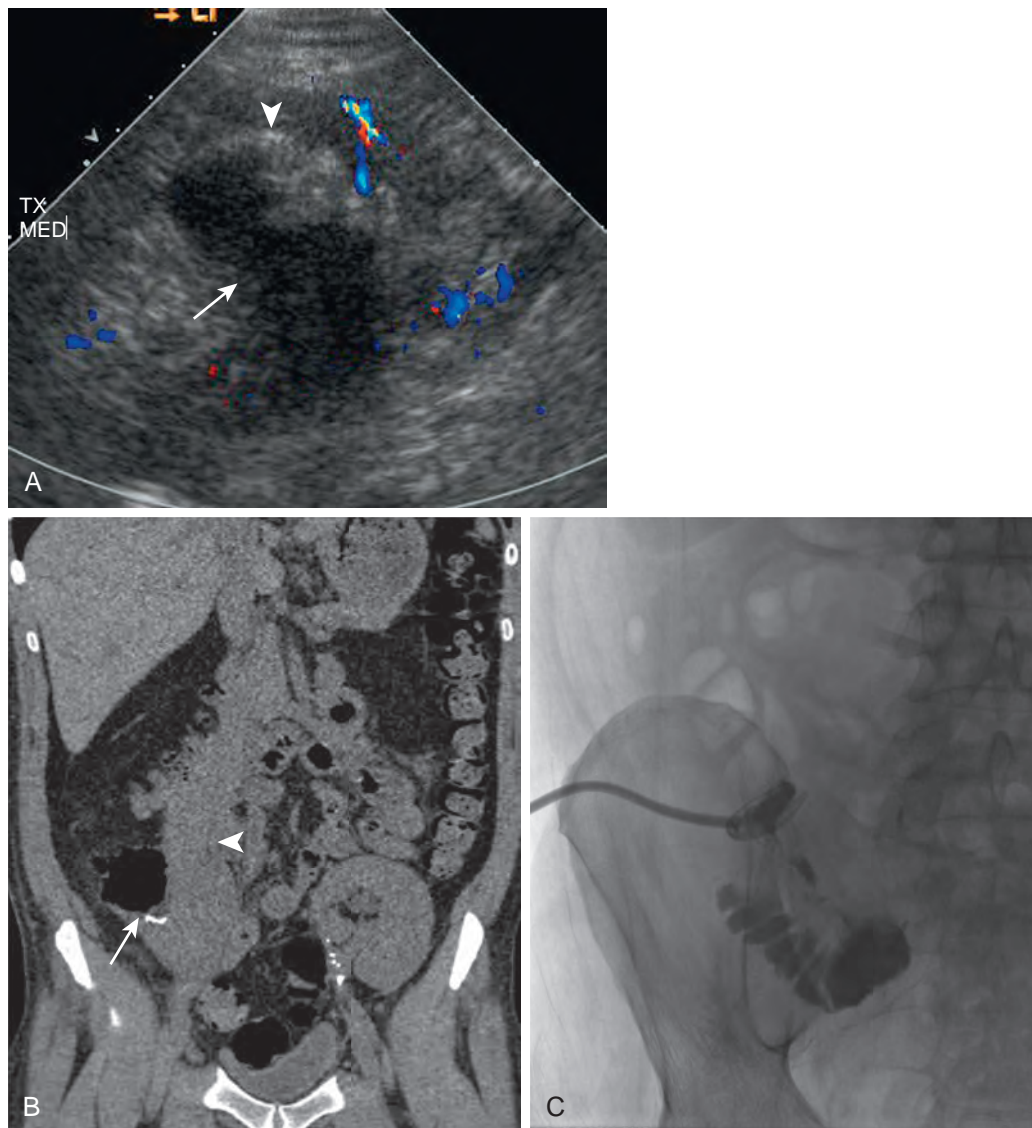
Duodenal anastomotic leak in a 53-year-old man after systemic venous–enteric PAK transplantation. A. Color Doppler US image shows an avascular complex fluid collection lateral to the pancreas transplant (arrow) with echogenic foci (arrowhead) in the nondependent portion, suggesting the presence of gas. B. Unenhanced CT better shows the gas-containing complex peripancreatic fluid collection, closely associated with the duodenal suture line (arrow), which aids in localizing the pancreas transplant (arrowhead). C. Sinogram obtained after injection of contrast material through the existing pigtail drainage catheter shows opacification of a loop of small bowel compatible with a duodenal anastomotic leak. (From Vandermeer F, Manning MA, Frazier A, et al: *Imaging of whole-organ pancreas transplants*. *RadioGraphics* 32:411–435, 2012.)
